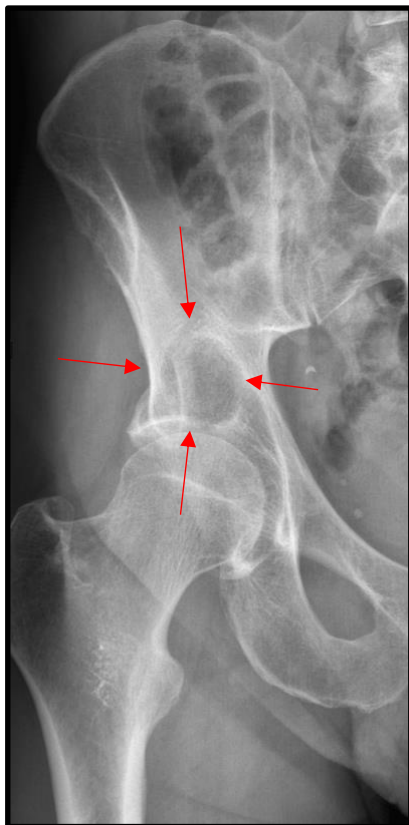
X-ray of a case of RDD in the right acetabular region of a male patient at the age of 49 years. The image shows a lytic lesion with well-defined boundaries. The lesion measures 2.8 cm in its proximodistal diameter and has a sclerotic rim. Moreover, a slight affection of the cortex can be observed.
